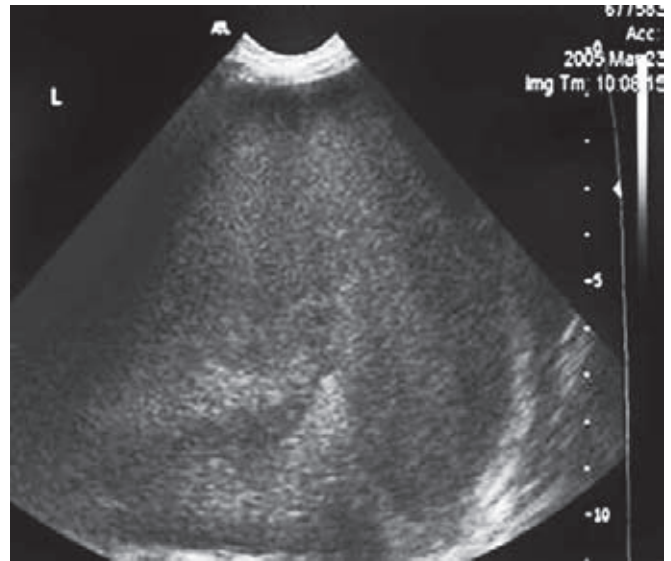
Ultrasound scan in the same patient as above shows debris in the pleural fluid
